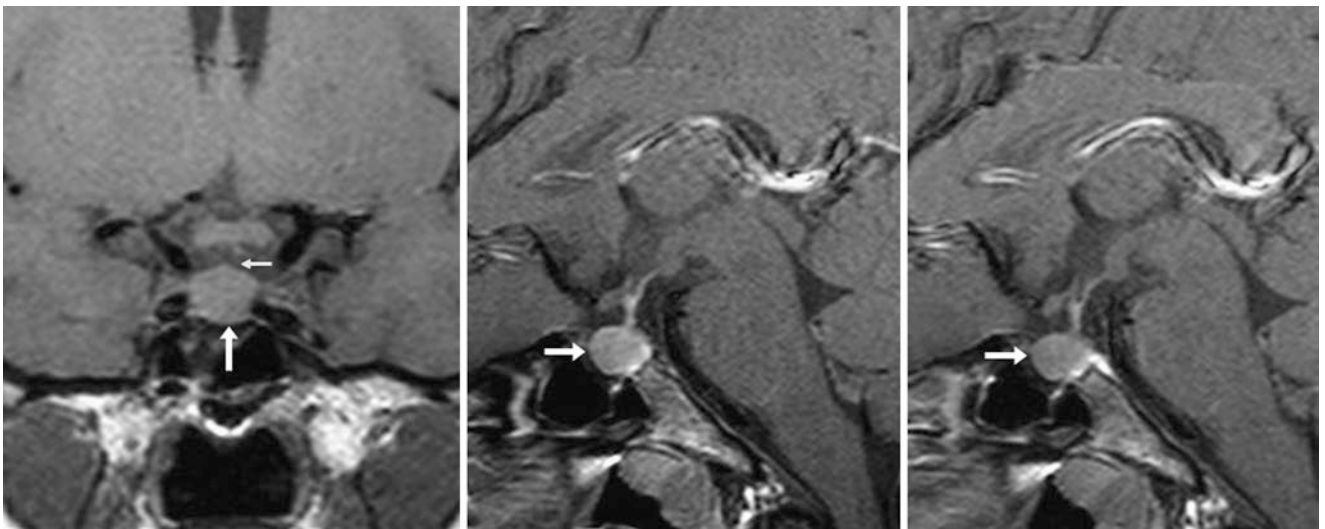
An 18-year-old female with right-sided headaches but an otherwise normal MRI. The mildly enlarged pituitary (*arrows*) on a 3 T MRI measured 10.3 mm in height on coronal noncontrast T1WI (*left*);
